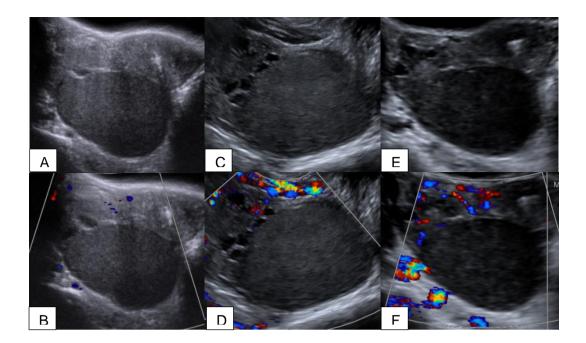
Female patients under 40 years of age who come to the emergency department reporting pelvic pain and transvaginal bleeding. Images A and C show pelvic exploration and image B transvaginal exploration in B mode, (B, D, and F in color Doppler mode); all the images show an ovary with an ovoid morphology image, with a ground-glass appearance, without color Doppler signal and that displaces the ovarian stroma, findings compatible with endometrioma.
